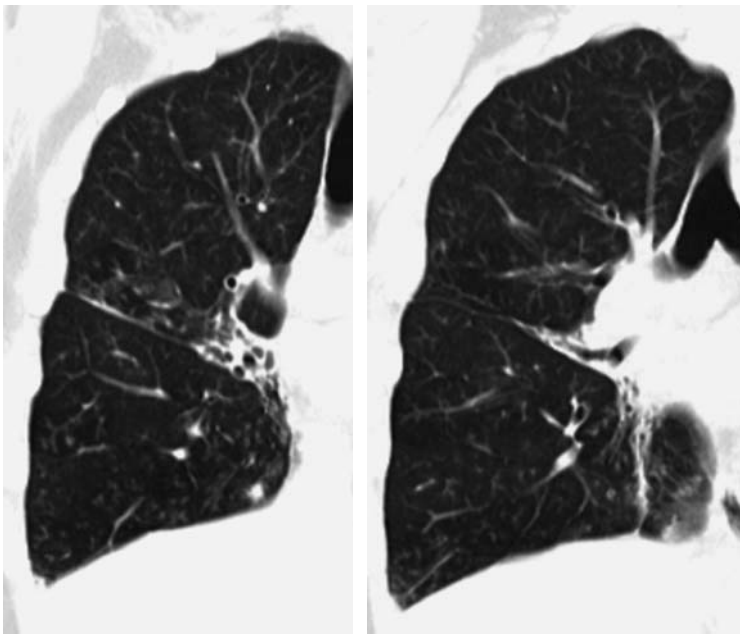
Coronal multiplanar reformation CT section of the right lung in lung transplantation recipient in inspiration (a) and expiration (b). Images show perihilar scarring and extensive peripheral tree-in-bud without any significant decrease in cross-sectional area in expiration
